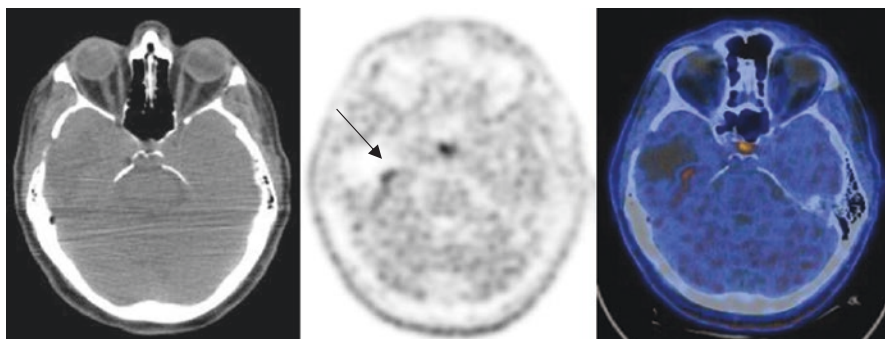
Astrocytoma III after surgery in a 41-year-old female. PET MET shows the presence of a small focus of faint uptake (SUVmax 2 T/B ratio 1.3) in the right temporal lobe. The finding is suspicious for initial local recurrence and deserves strict monitoring (case courtesy of Dr. Castellucci, University St. Orsola Malpighi, Bologna, Italy)
